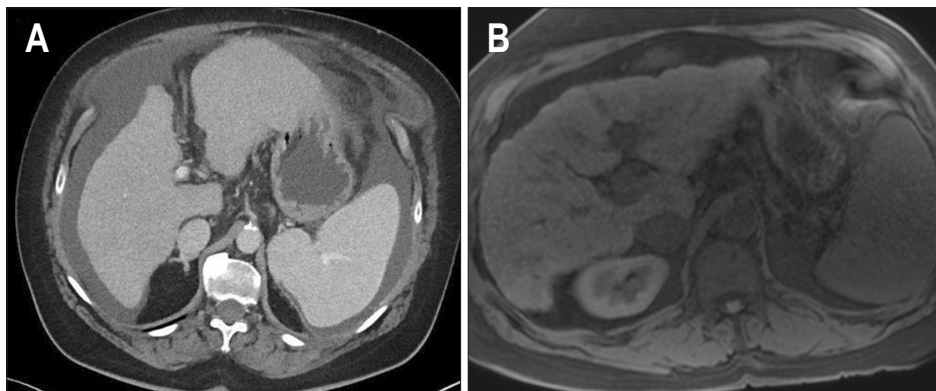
Morphological changes of cirrhosis. Axial computed tomography (A) and T1W fat saturated (B) images (from two different patients) show morphological changes associated with cirrhosis including nodular liver margins, left lobe hypertrophy, fissure widening and prominence of fat at the hepatic hilum.
